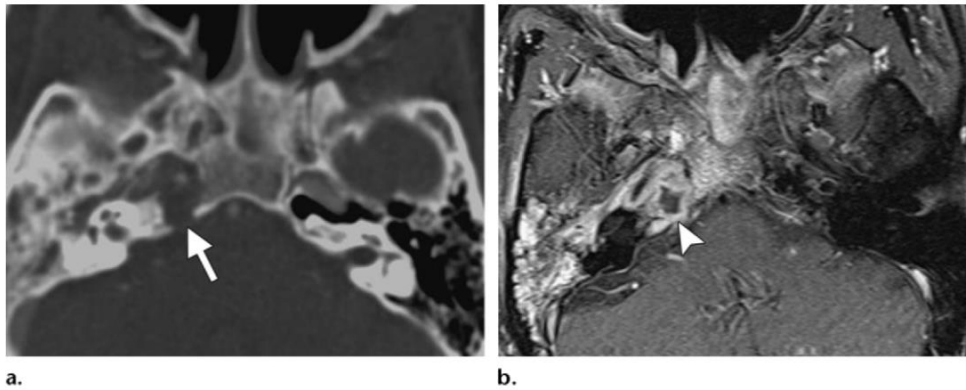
Petrous apicitis. (a) Axial contrast-enhanced CT image shows opacification of the right mastoid, middle ear, and anterior petrous air cells. There is cortical erosion along the posterior margin of the petrous apex (arrow). Note the pneumatization of the left petrous apex. (b) Gadolinium-enhanced fat-suppressed T1-weighted MR image shows diffuse enhancement throughout the right mastoid and middle ear, anterior petrous apex, and clivus. There is also a focal rim-enhancing fluid collection in the anterior petrous apex (arrowhead), a finding consistent with an abscess.
